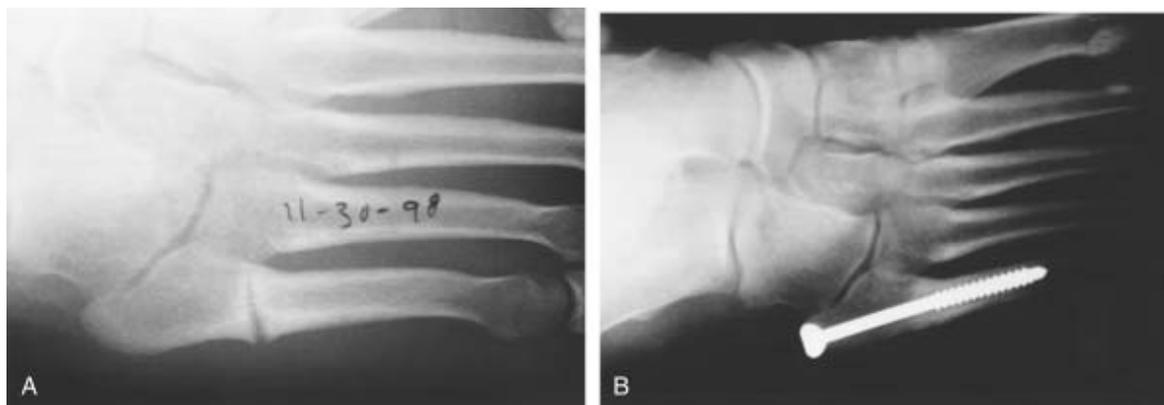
Figure 25C2-13 A, This patient sustained a fracture of the diaphysis of the fifth metatarsal. This is the radiograph 2 months after treatment with a cast. The metatarsal was tender to palpation, and the patient walked with a limp. B, This radiograph was taken after treatment with internal fixation and local bone graft from the calcaneus.
